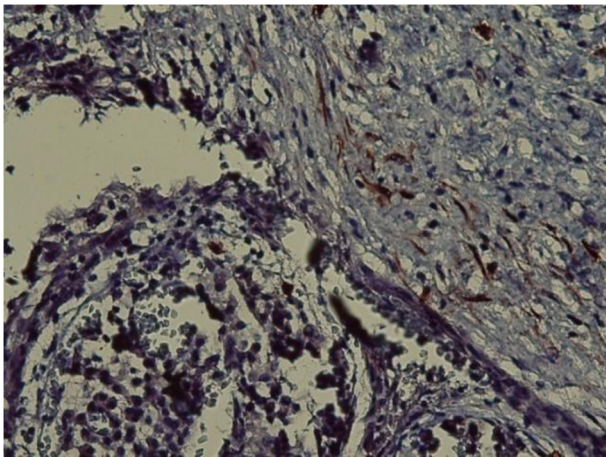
Immunoreactivity of the C-KIT (CD117) in Periapical Cyst ($\times 400$)
